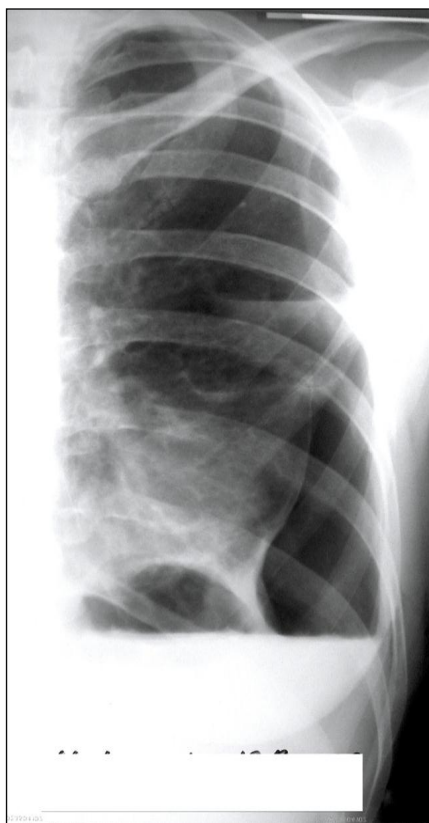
Radiography after creation of artificial pneumothorax.
